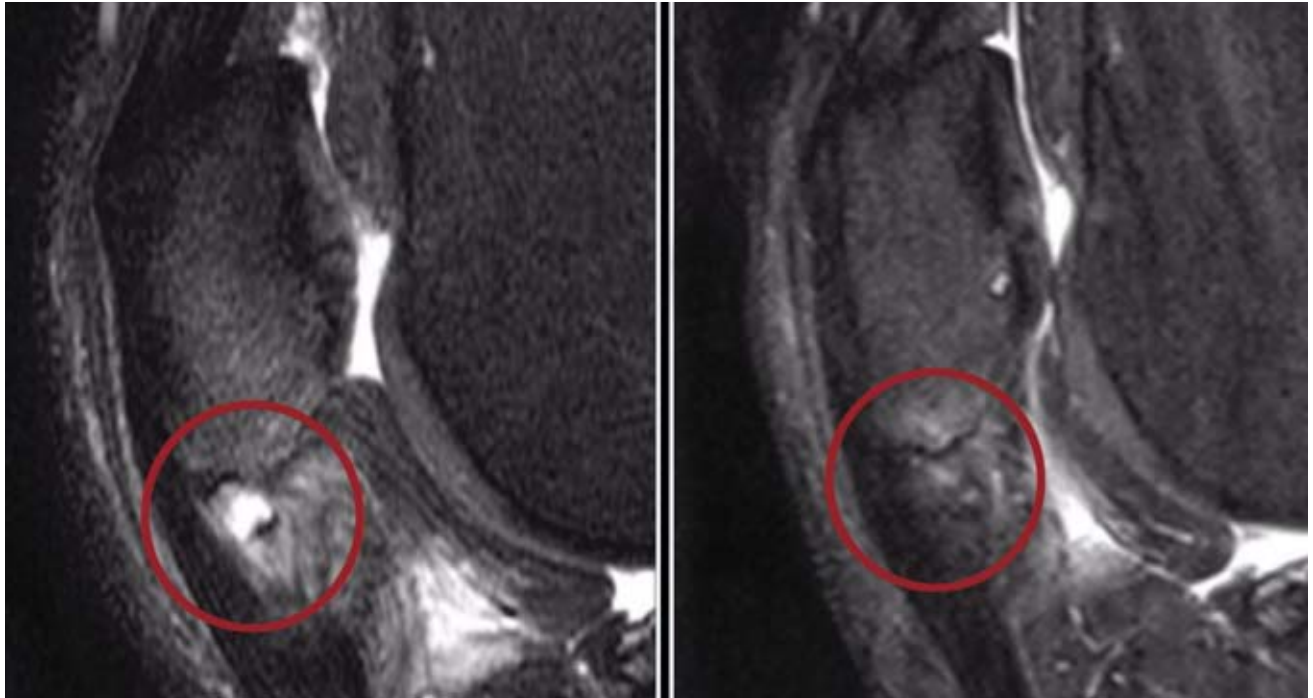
A 42-year-old man with patella tendon tear (left). Over the course of 1 year, the man received 3 ultrasound-guided platelet-rich plasma injections with magnetic resonance imaging showing near complete resolution (right).
